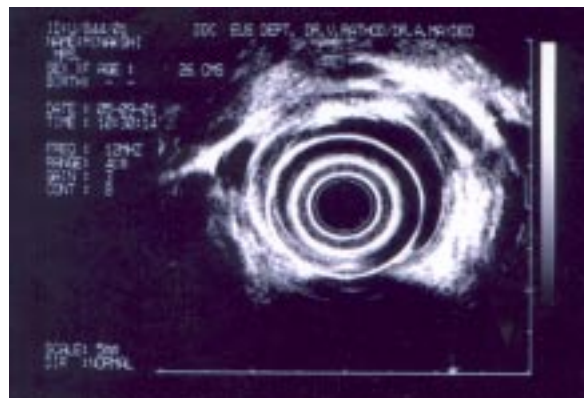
Endoscopic ultrasound picture suggestive of a healing ulcer
